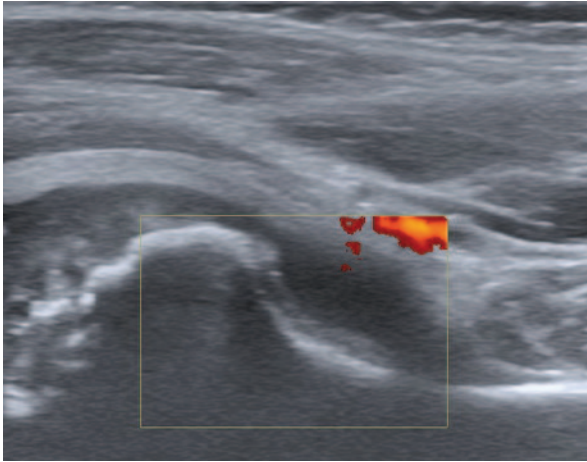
Legg–Perthes–Calvé disease. Longitudinal US scan of the hip joint shows hypoechoic effusion (*Eff*). The hyperechoic surface of the epiphyseal cartilage of the femoral head is not visible due to the disease. Note irregularities in femoral head contour because of fragmentation of epiphysis and deformity. Doppler was applied towards the anterior and posterior layers of capsule in order to identify active synovial membrane but only a vessel is detected outside of capsule
